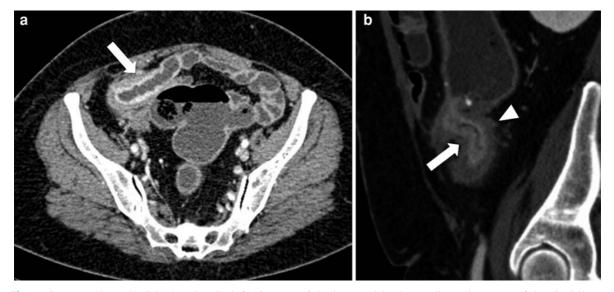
Contrast-enhanced axial (a) and sagittal (b) CT scan of the lower pelvis show a diseased segment of the distal ileum (*arrow*) with stratified mural thickening, mural ulceration and fibrofatty proliferation (*arrowhead*)
